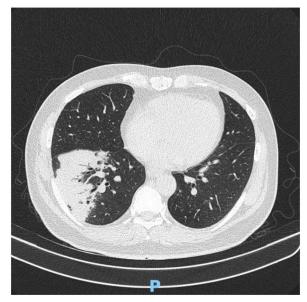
Chest CT-scan obtained 14 days after admission. Significant consolidation lesions in the right upper and lower lobes compared to the most recent images, which were more severe than 14-day prior CT-scan.
